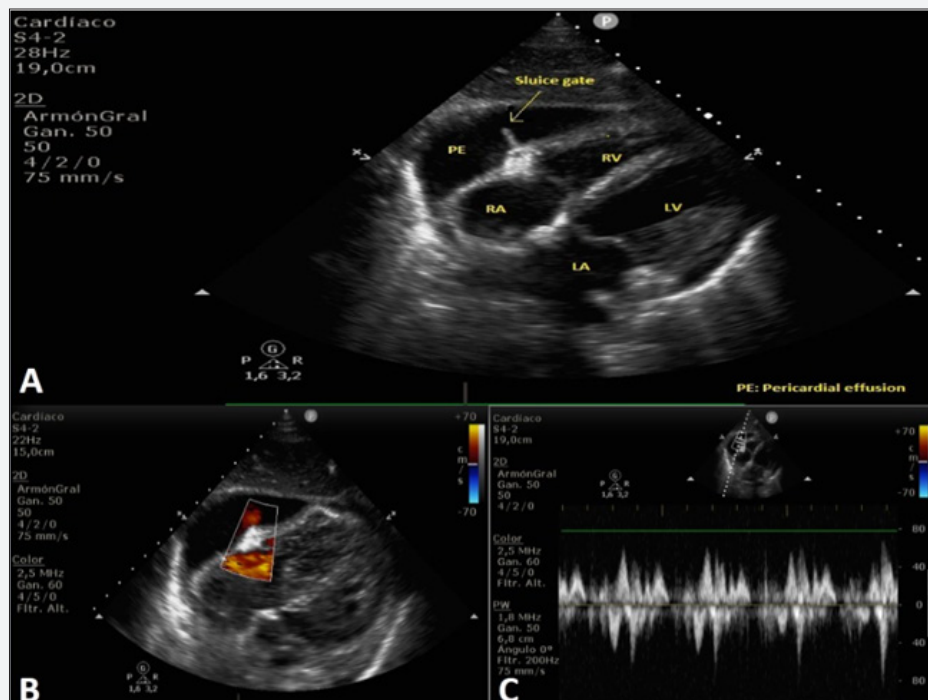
Panel A: 2D echocardiography with pericardial effusion and fibrin tracts.
